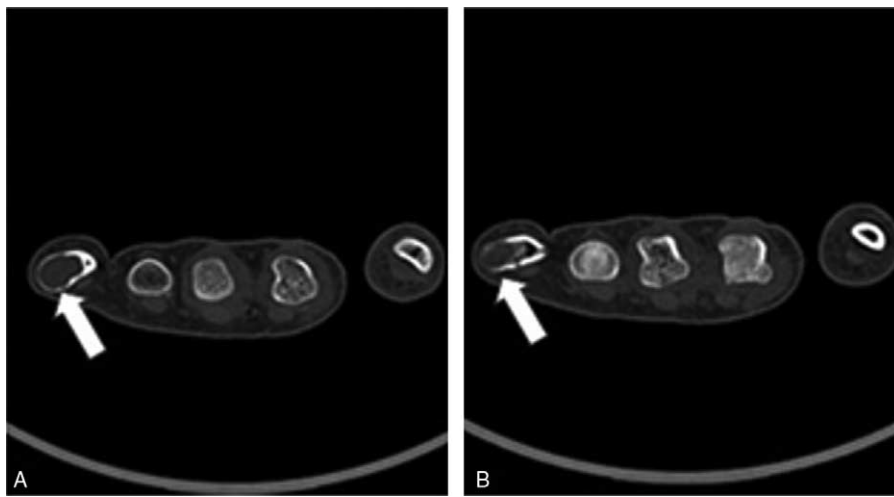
The initial CT image of the left hand obtained showed the presence of a low-density tumor of approximately 1.0×1.3 cm in the fifth proximal phalanx, on the left side where the cortical bone was dilated and thinned.
